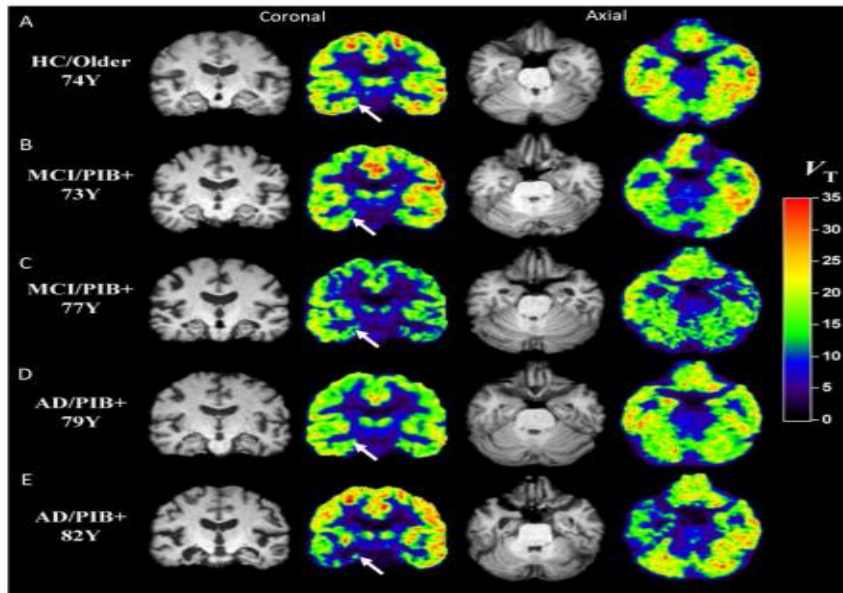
Representative coronal and axial images of ^{11}C -UCB-J parametric PET (V_T) and MRI scans in CN (A), MCI (B, C), and mild AD dementia (D, E). The CN had a negative ^{11}C -PiB scan and all AD had positive ^{11}C -PiB scans. The pseudo-color in PET images represents the intensity of UCB-J binding (V_T) with reference value displayed on the color bar. Evident reduction of ^{11}C -UCB-J binding in the hippocampus of AD was noted as compared to CN (see arrow for the region of right hippocampus). Various degrees of reduction can be visualized in the temporoparietal cortex of MCI (B, C) and mild AD dementia (D) and right temporal cortex of participant E.
